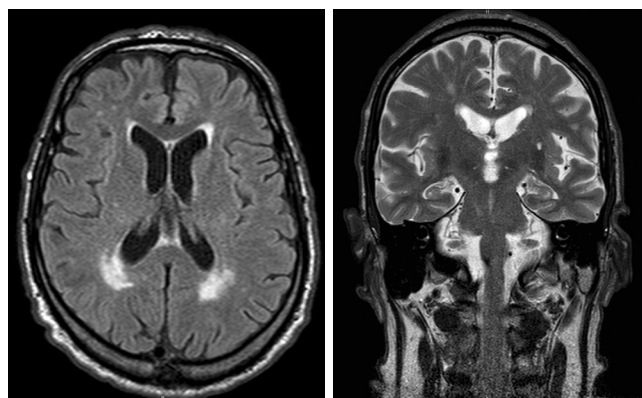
Periventricular hyperintensity of vascular origin on T2 (A) and FLAIR (B) MRI scans of the patient's brain.
